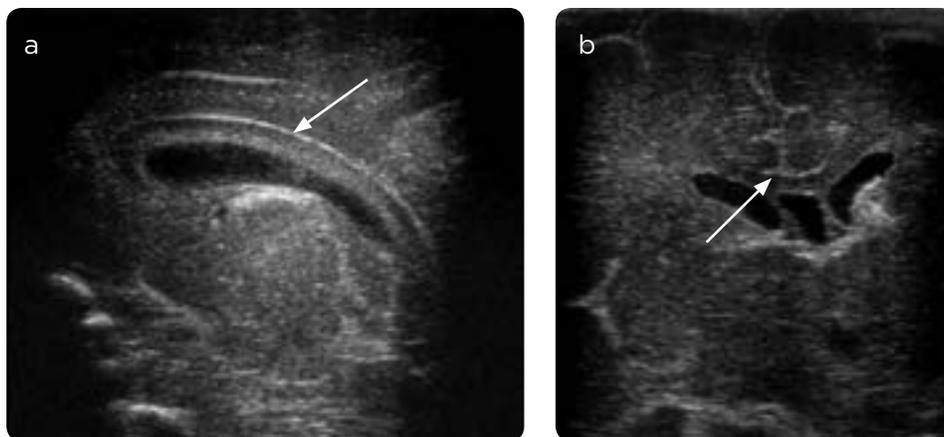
a) Transfontanellar ultrasound, sagittal, anterior fontanel: normal corpus callosum (arrow). b) Transfontanellar coronal ultrasound, anterior fontanel: normal corpus callosum (arrow).
